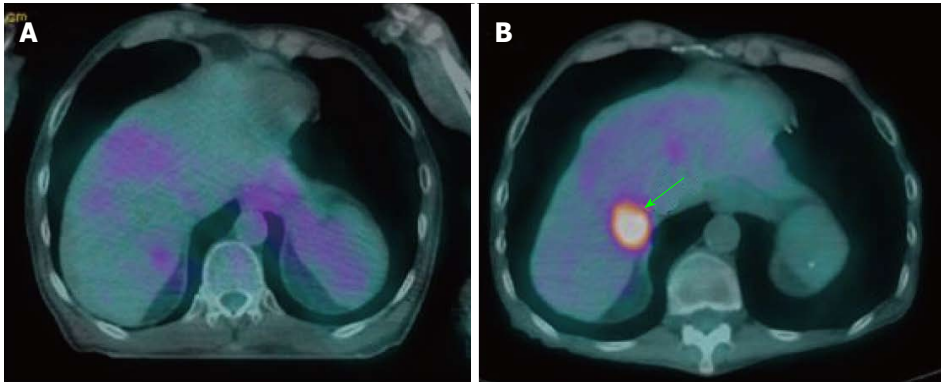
Failure of treatment due to distant metastasis. A: Pre-treatment PET/CT of the patient with squamous cell carcinoma of the base of tongue in Figure 6 did not reveal any increased FDG uptake in the liver; B: PET/CT performed at 13 mo after treatment showed new hepatic metastasis (arrow), representing treatment failure. PET/CT: Positron-emission tomography/computed tomography; FDG: 2-fluoro-2-deoxy-D-glucose.
